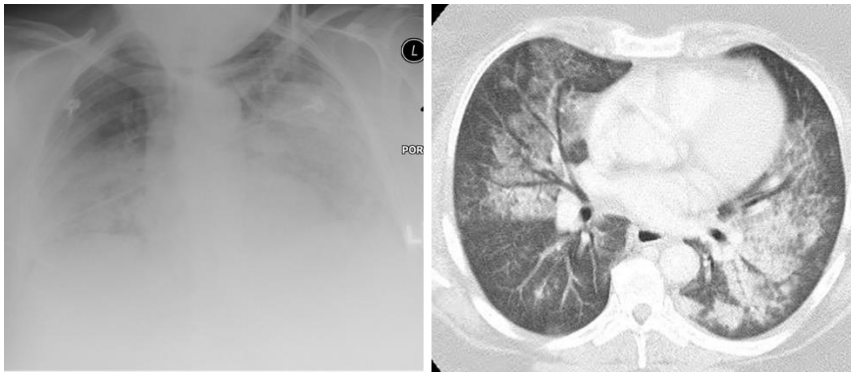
Diffuse alveolar hemorrhage in a patient with granulomatosis with polyangiitis (left: chest X-ray with diffuse infiltrate; right: diffuse ground-glass opacities and infiltrates on axial CT scan).
